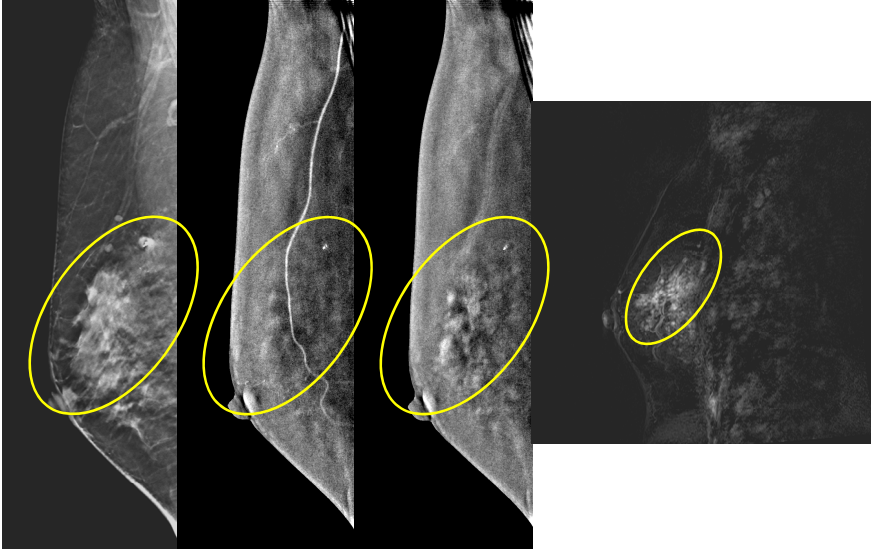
DCIS. Segmental clumped enhancement in the upper breast. From left to right: Pre-contrast low energy DBT, Post-contrast DE subtraction at 20 s, Post-contrast DE subtraction at 3 m 25 s, and subtraction image from breast MRI at 3 min. Clip at site of prior biopsy.
